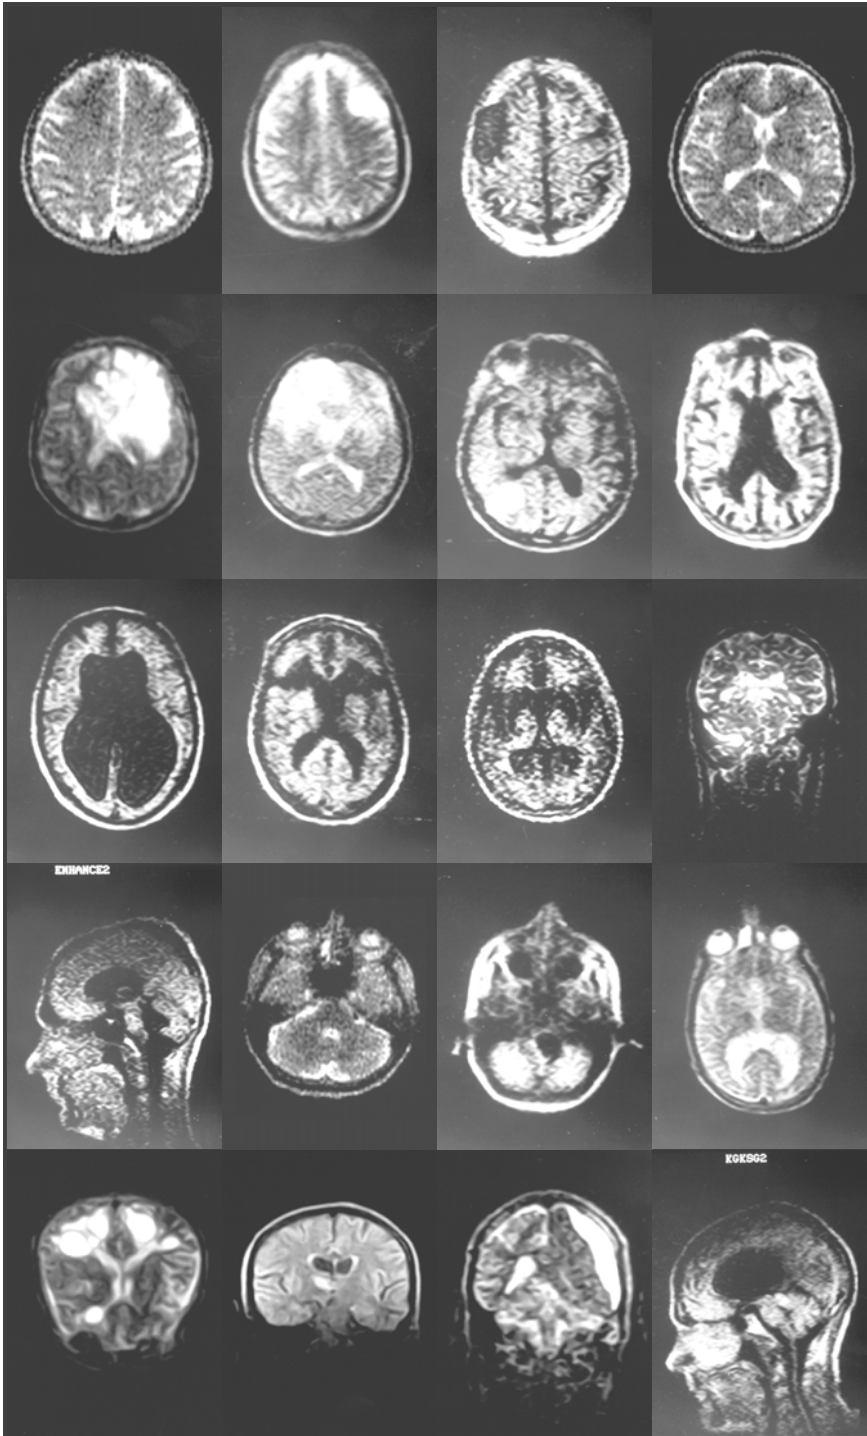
A gallery of brain portraits. Montage from a selection of photos of MRI scans performed at St. Görän's in the 1980s.⁴⁵
